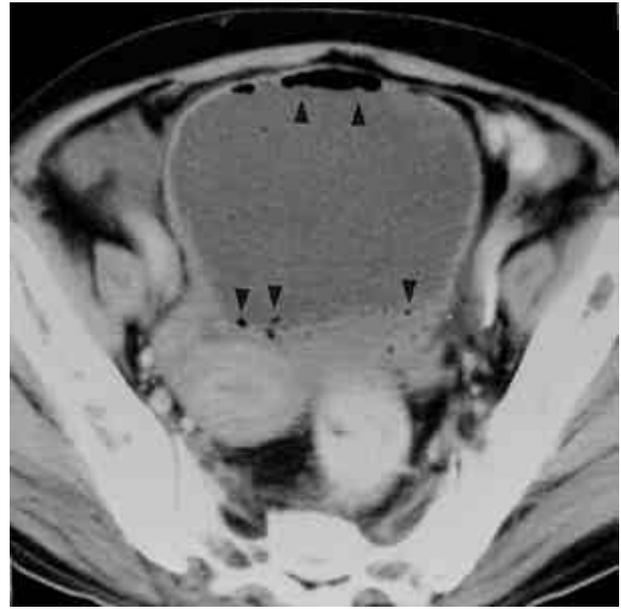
Postcontrast pelvic CT scan shows mottled gas bubbles within the wall of the bladder (arrow heads).
